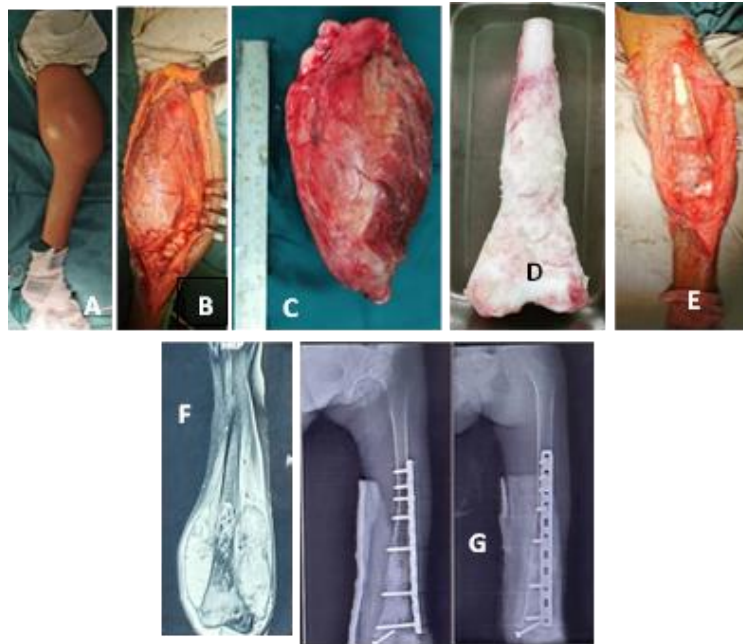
A. Clinical photo of a 9-year-old female with osteosarcoma involving distal femur; B. Intraoperative view of the tumor. C. Post-resection of the tumor. D. Post-submersion in liquid nitrogen. E. Clinical view post internal fixation. F. CT-imaging of preoperative state. G. X-ray imaging post internal fixation.
